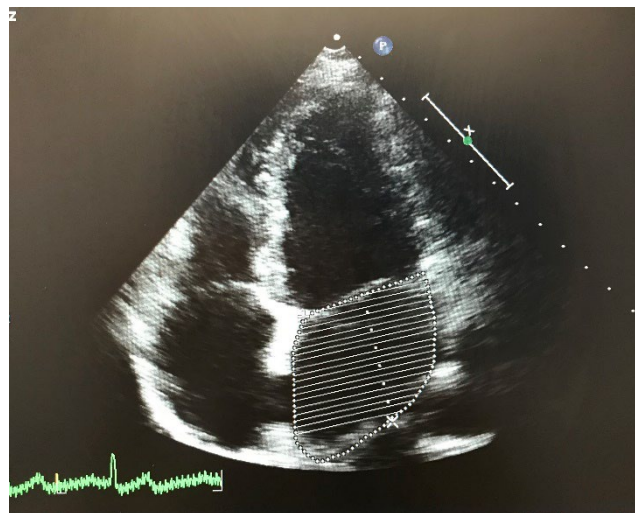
Apical four chamber view of left atrial volume
